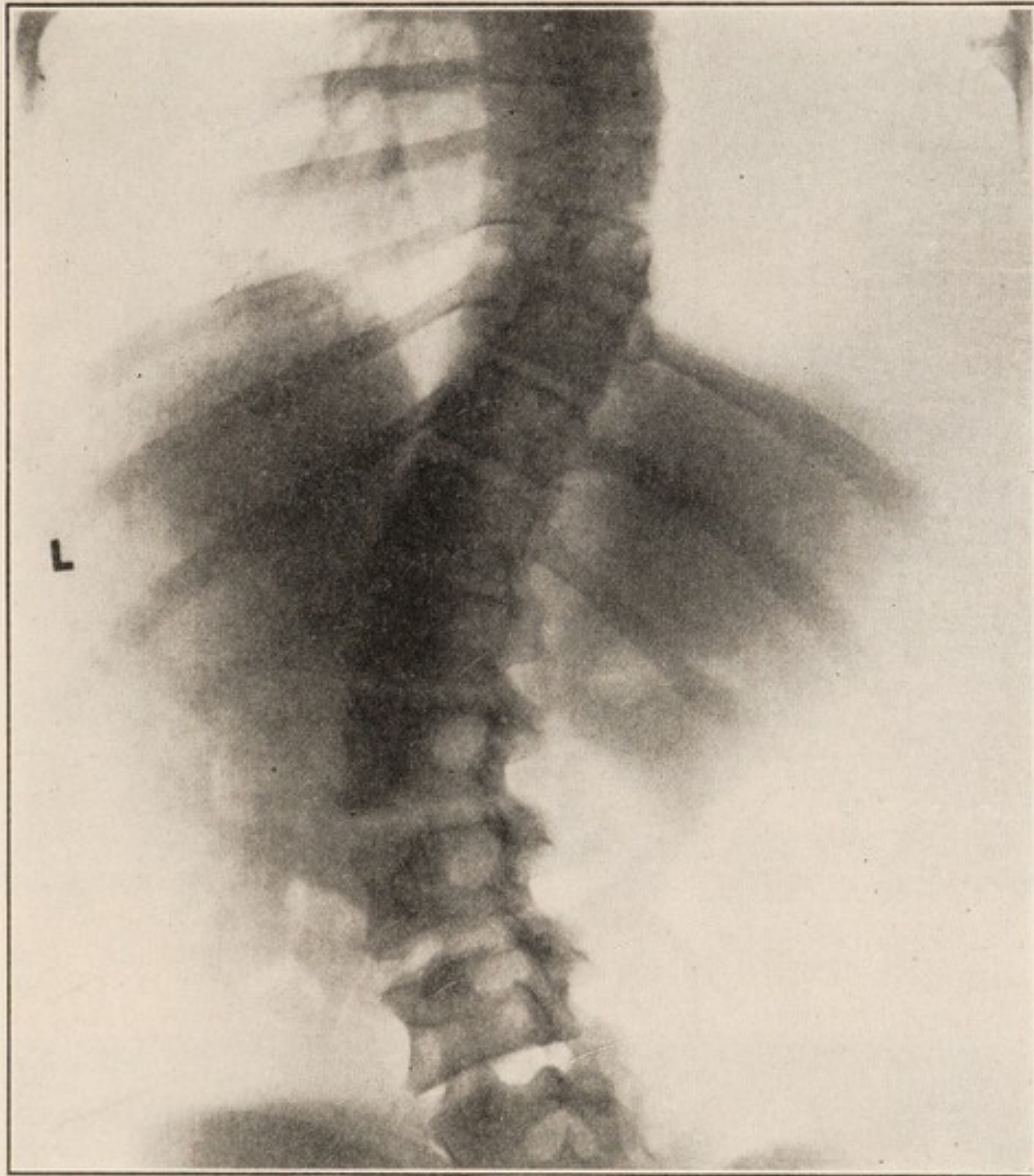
X-ray of patient shown in Fig. 259 before application of forcible correction.
